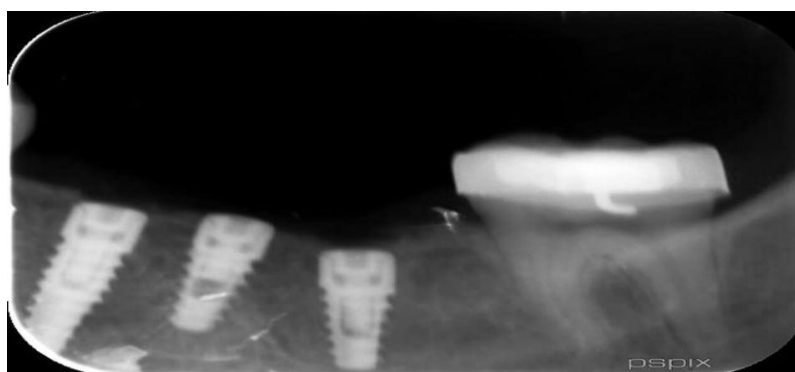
Retroalveolar roentgen image taken right after the intervention
